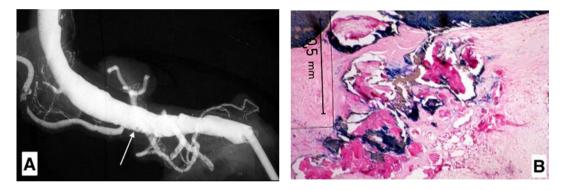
is the dissected, decalcified, proximal left coronary artery showing an occlusive thrombosis, the culprit lesion (long white arrow). Figure 1B shows an UP in the proximal circumflex coronary artery (short white arrow in Figure 1A) without significant luminal stenosis or thrombosis. The black arrow indicates a focus of inflammation. Figure 1C is the X-ray of the proximal segment of the dissected, decalcified right coronary artery showing no evidence of luminal
